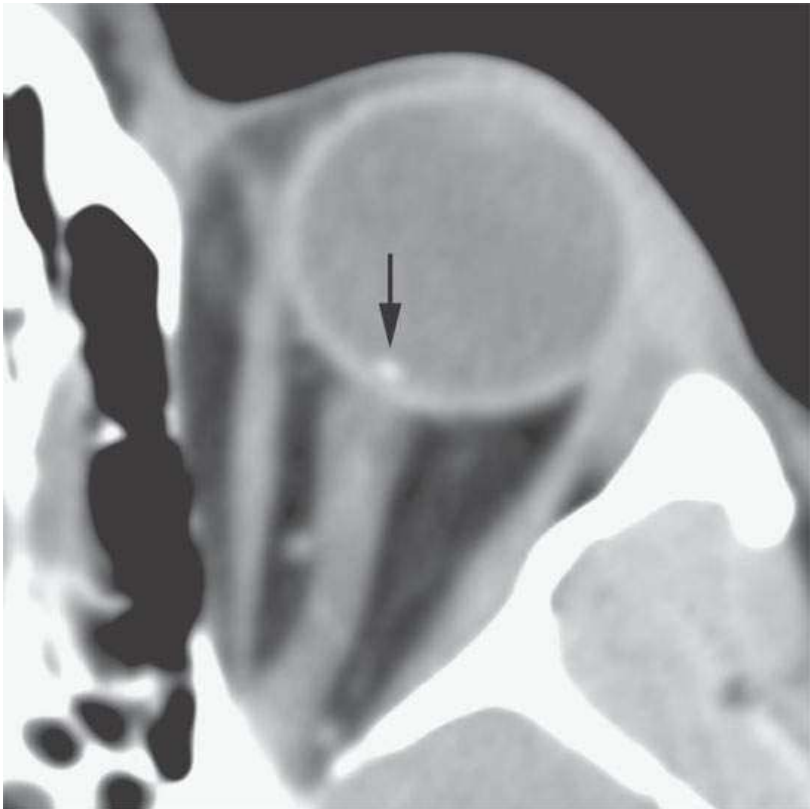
Computed tomography of an optic nerve Drusen (arrow).
